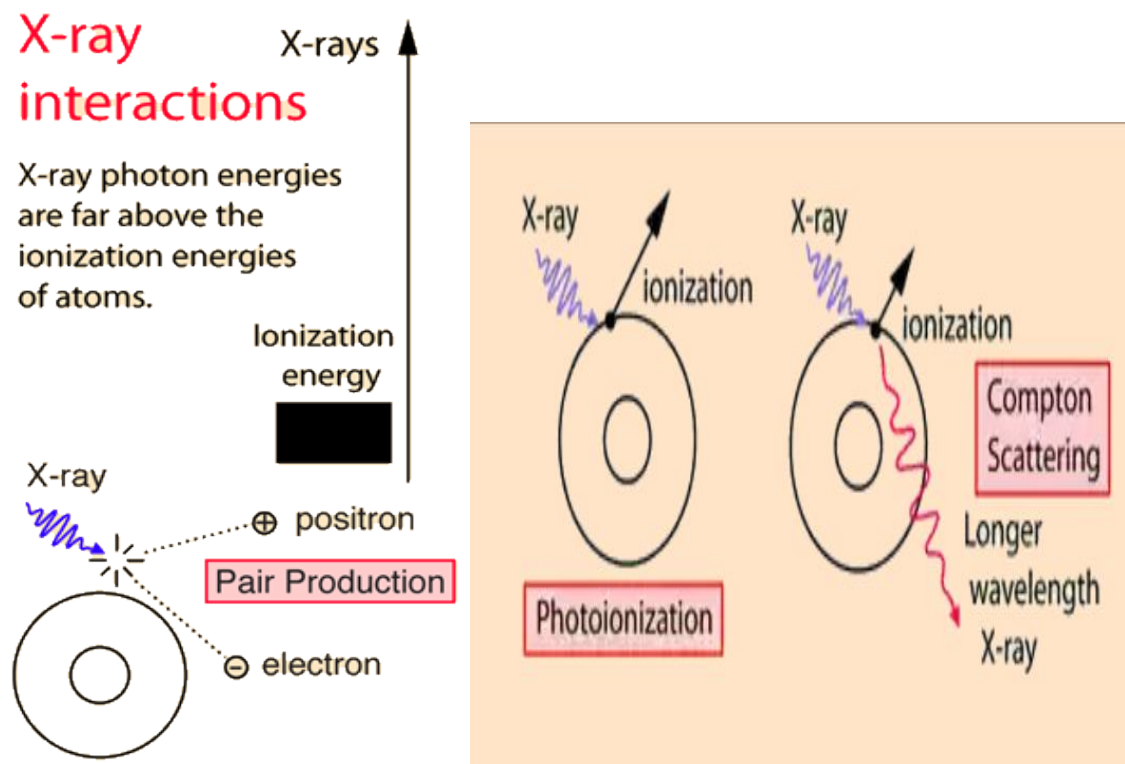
x-Ray Interaction with Matter (Nave, 2017).
